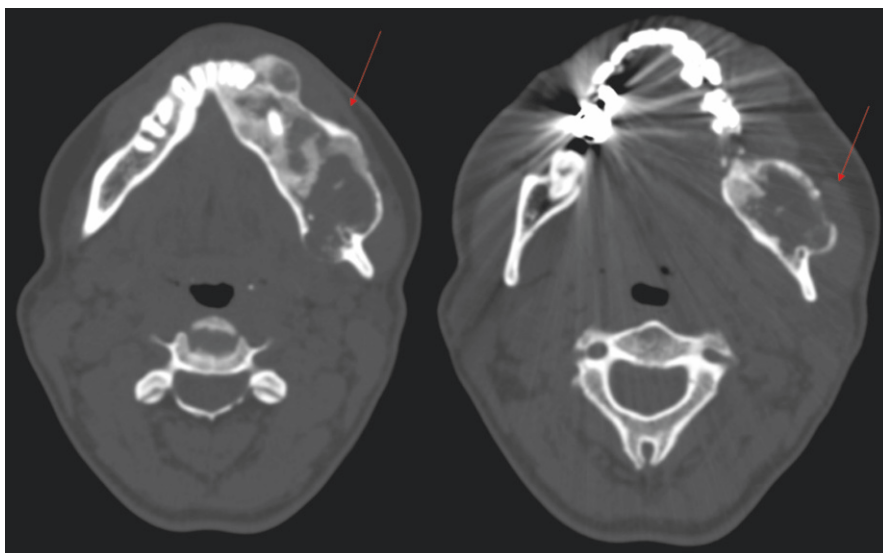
Maxillofacial axial computed tomography of the patient from Fig. 11.4. Notice classic “ground glass” appearance and cortical expansion (*arrows*)
